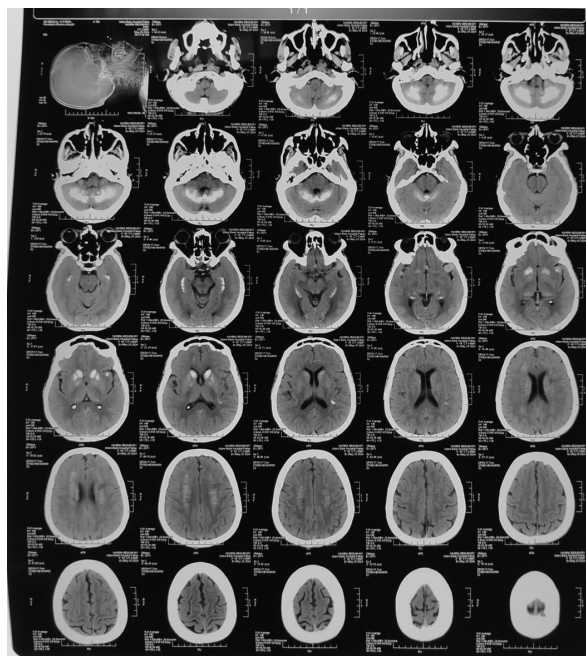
Axial view of Brain CT showing irregular bilateral symmetrical calcifications in basal ganglia, thalami, cerebellum and corona radiata
